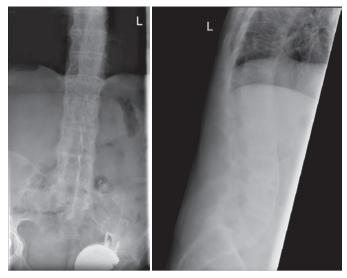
AP and lateral radiographs demonstrating bamboo appearance AS spine
